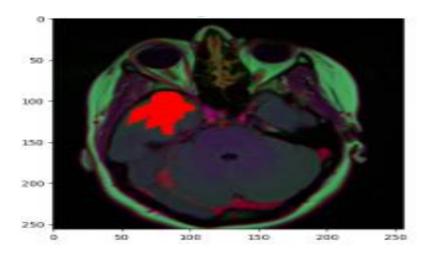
Brain MRI with original mask
